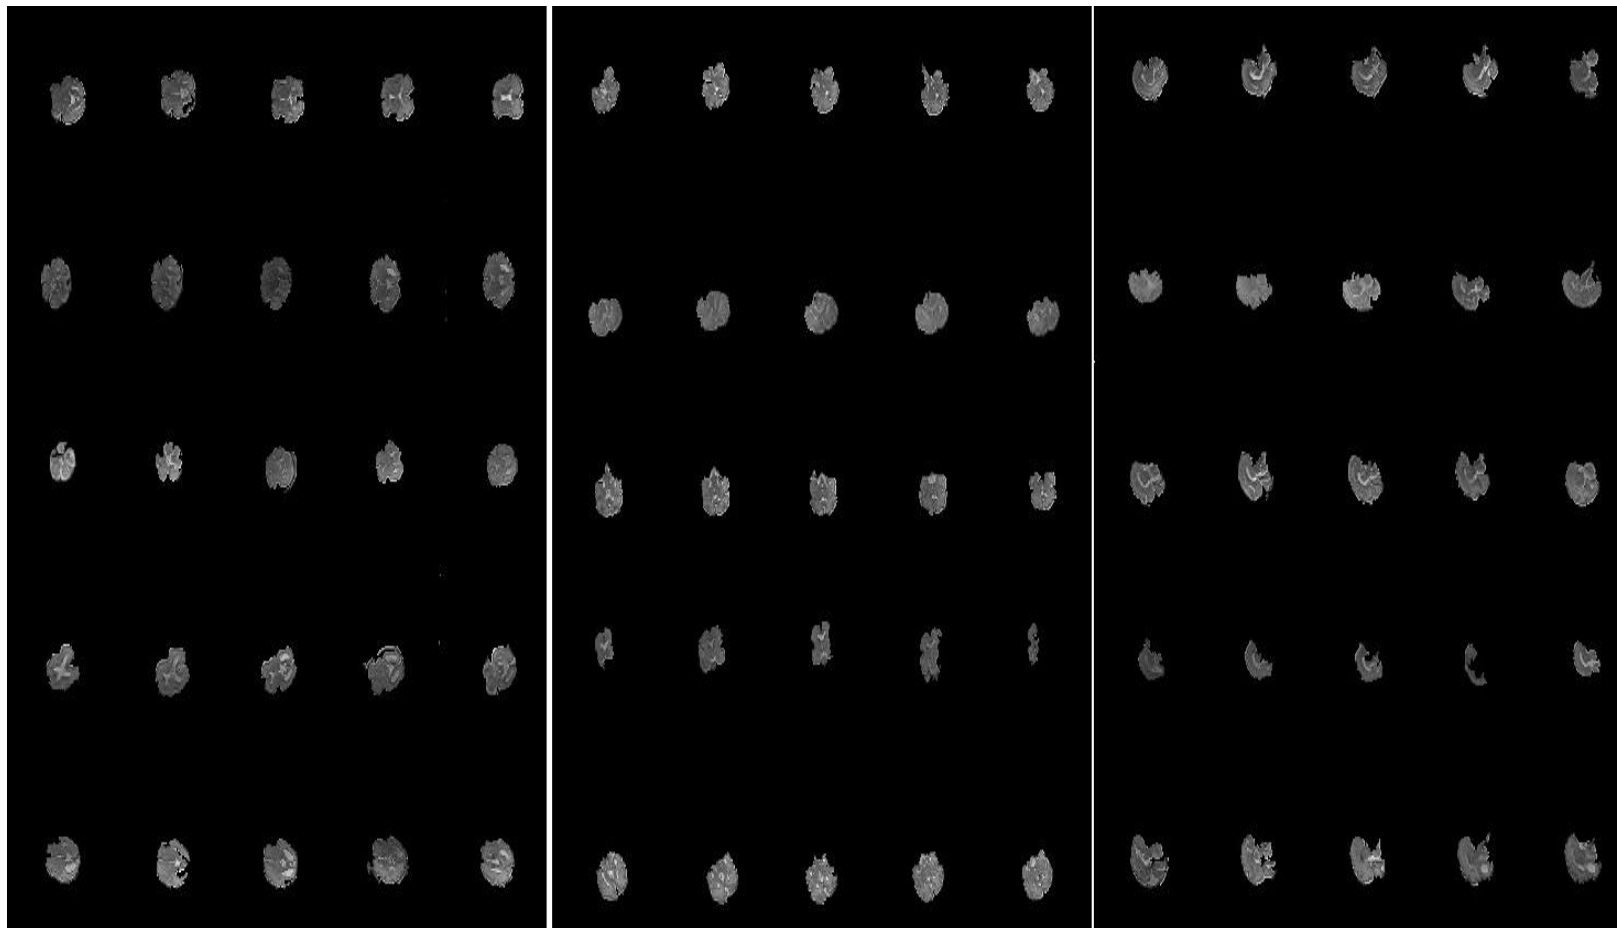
ROI of MR images achieved in a) Axial plane b) Coronal plane and c) Sagittal plane
